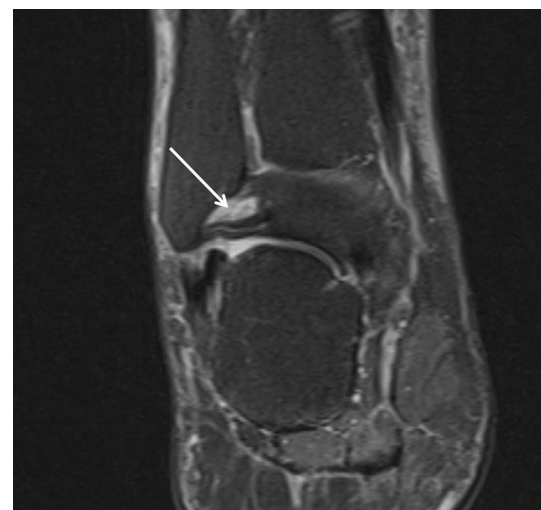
Coronal PD FS MR image: the posterior tibiotalar ligament (*arrow*) appears as a hypointense band overlying a thin layer of effusion. This ligament is poorly visualized on ultrasound, but it is rarely involved in ankle sprains
